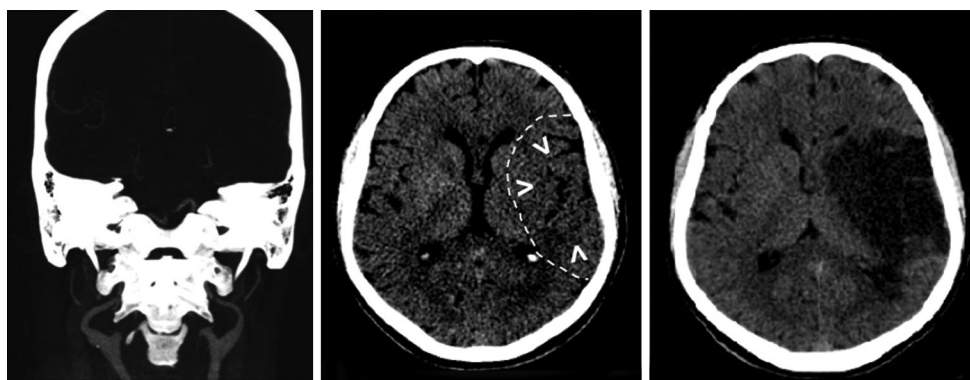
A 66-year-old man presented within 90 minutes of onset of right hemiplegia and aphasia. (A) Coronal CTA MIP image with unremarkable findings of the cervical carotid arteries; (B) Noncontrast CT demonstrates subtle effacement of the left insular cortex (arrowheads). Dotted line demonstrated a more extensive ischemic area according to the follow-up exam; and (C) Imaging follow-up after 2 days confirmed a large infarct in the MCA territory. A cardiac source of emboli was confirmed.
